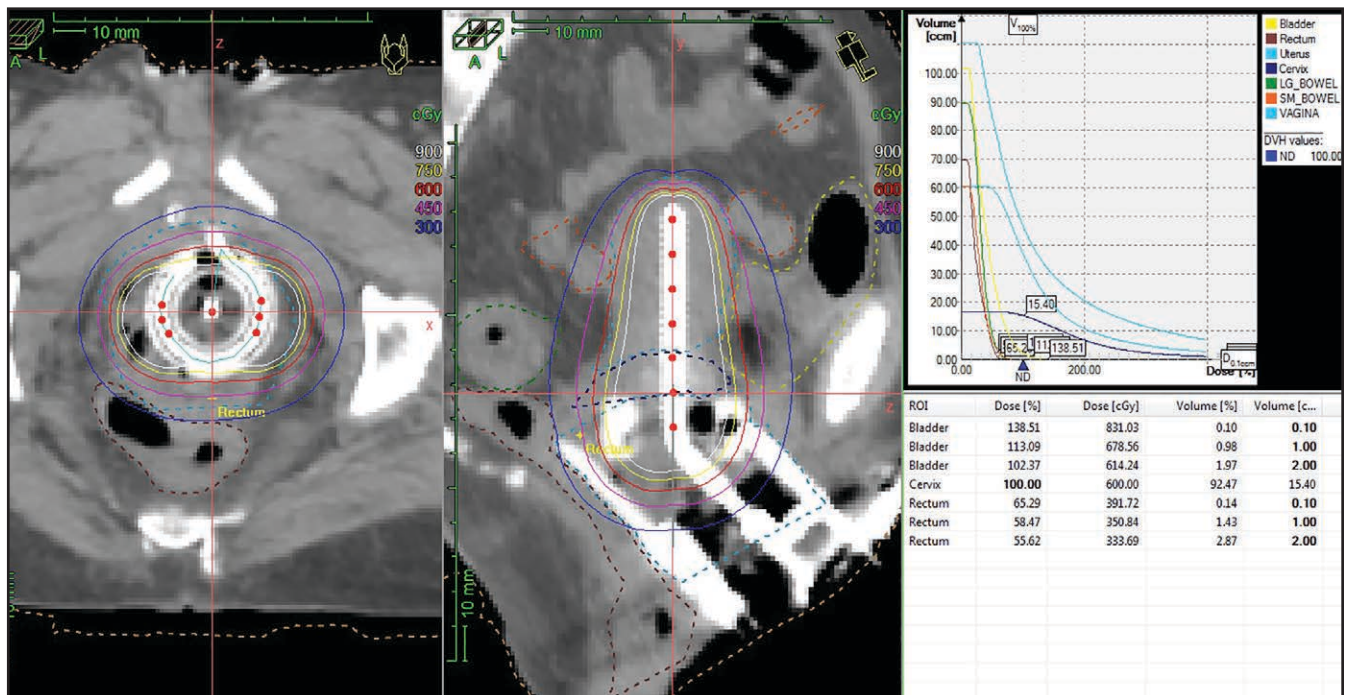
Tandem and ring applicator with DVH using CT-based planning for a FIGO stage IIB cervical cancer.
